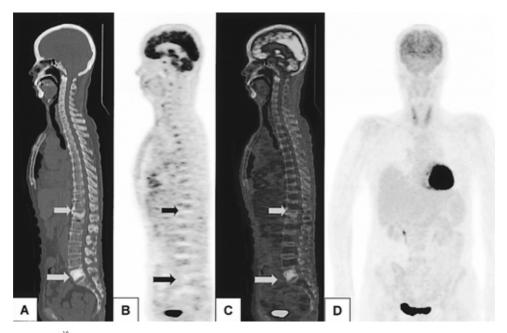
The ¹⁸F-FDG PET/CT was obtained for further evaluation for other involvement lesions. There was no significant FDG uptake in L5 (osteosclerotic myeloma) and T12 spine (old compression fracture)(Fig 2, arrows point to lesion on from A to D, CT, PET, fusion image and whole body PET image). The patient underwent chemotherapy and radiotherapy on L5 spine as planned.
